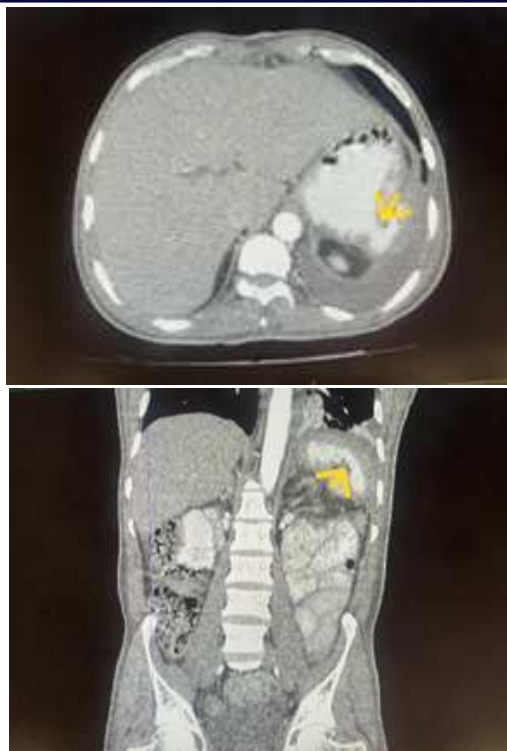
CT image showing contrast leak stomach into the collection.
